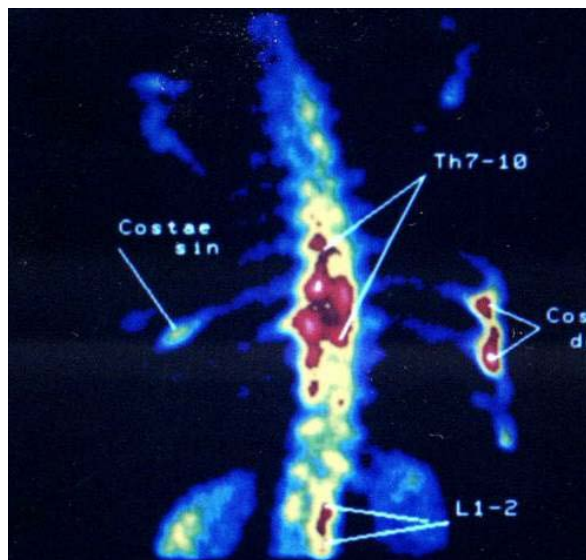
Radionuclide bone imaging (osteoscintigraphy), with ^{99m}Tc -methylene diphosphonate. Hyperfixing in chest and lumbar departments of the backbone; in ribs from both parties. Signs of metastases of a malignant tumour in a bone
